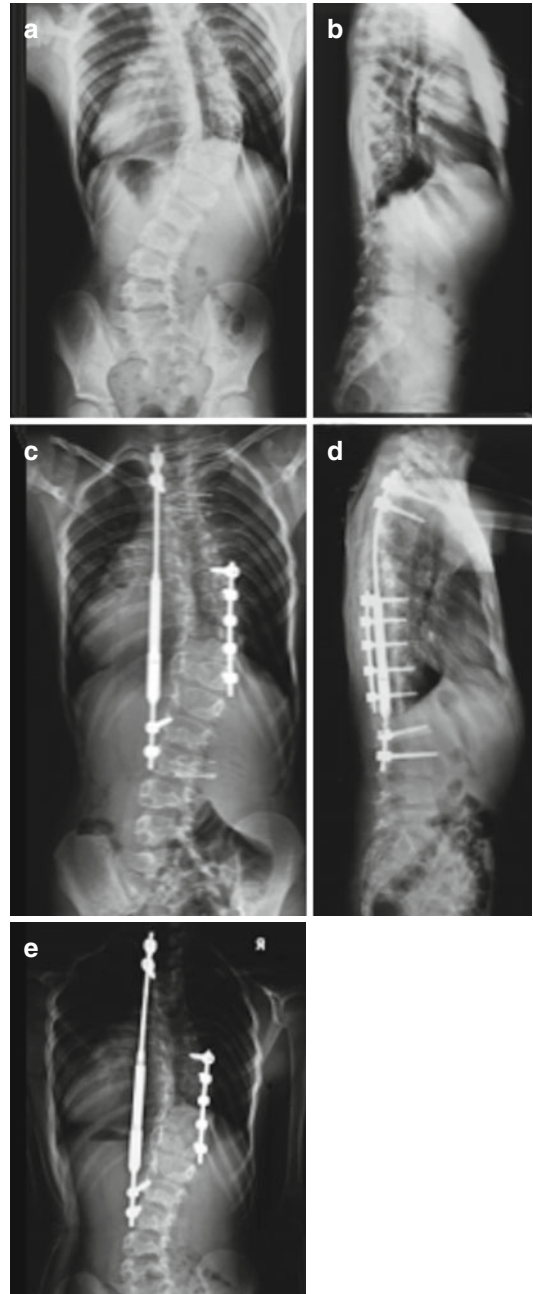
Anteroposterior (AP) (a) and lateral (b) radiographs of a 6-year-old female with previous thoracic diastematomyelia spur excision. Her progressive long sweeping congenital curve was addressed with instrumented convex hemiepiphysiodesis and concave distraction using a magnetically controlled growing rod. Postoperative radiographs show satisfactory alignment in anteroposterior (c) and lateral (d) views. At 6-month follow-up, the AP radiograph showed further correction (e) with maintenance of sagittal alignment (not shown). The patient underwent three distractions during the 6-month follow-up at 2-month interval clinic visits using the magnetic rod remote controller
